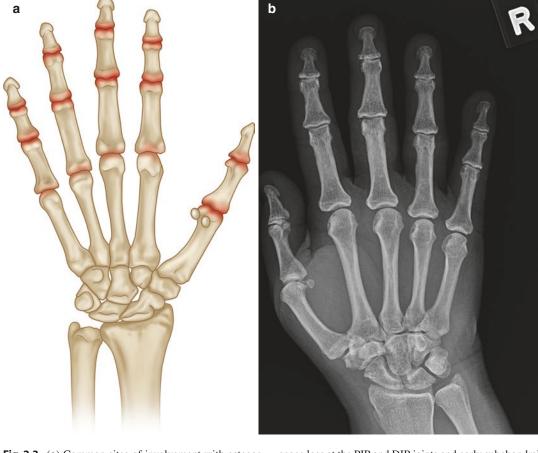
(a) Common sites of involvement with osteoarthritis of the hand (*highlighted in red*). (b) PA radiograph of right hand with early osteoarthritis demonstrating joint
